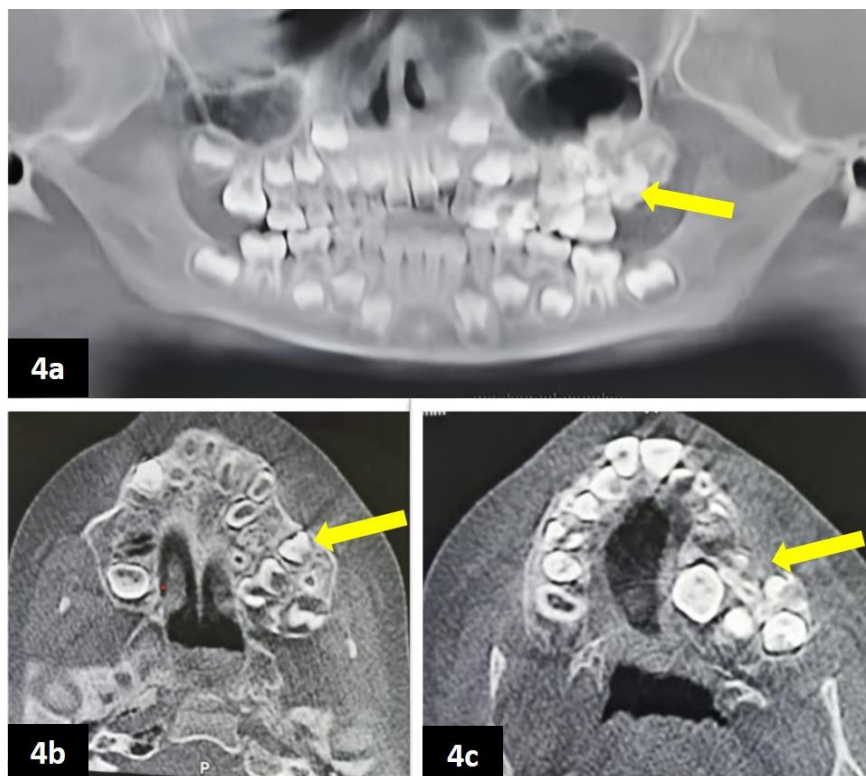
CBCT (Cone Beam Computed Tomography) images showing segmental odontomaxillary dysplasia involving the left maxilla. a: Panoramic radiograph reveals malformed and delayed-erupting teeth in the left posterior maxilla (yellow arrow), b-c: Axial CBCT slices demonstrate buccolingual expansion, increased bone density with coarse, irregular trabeculae in the affected maxillary segment (yellow arrows)
